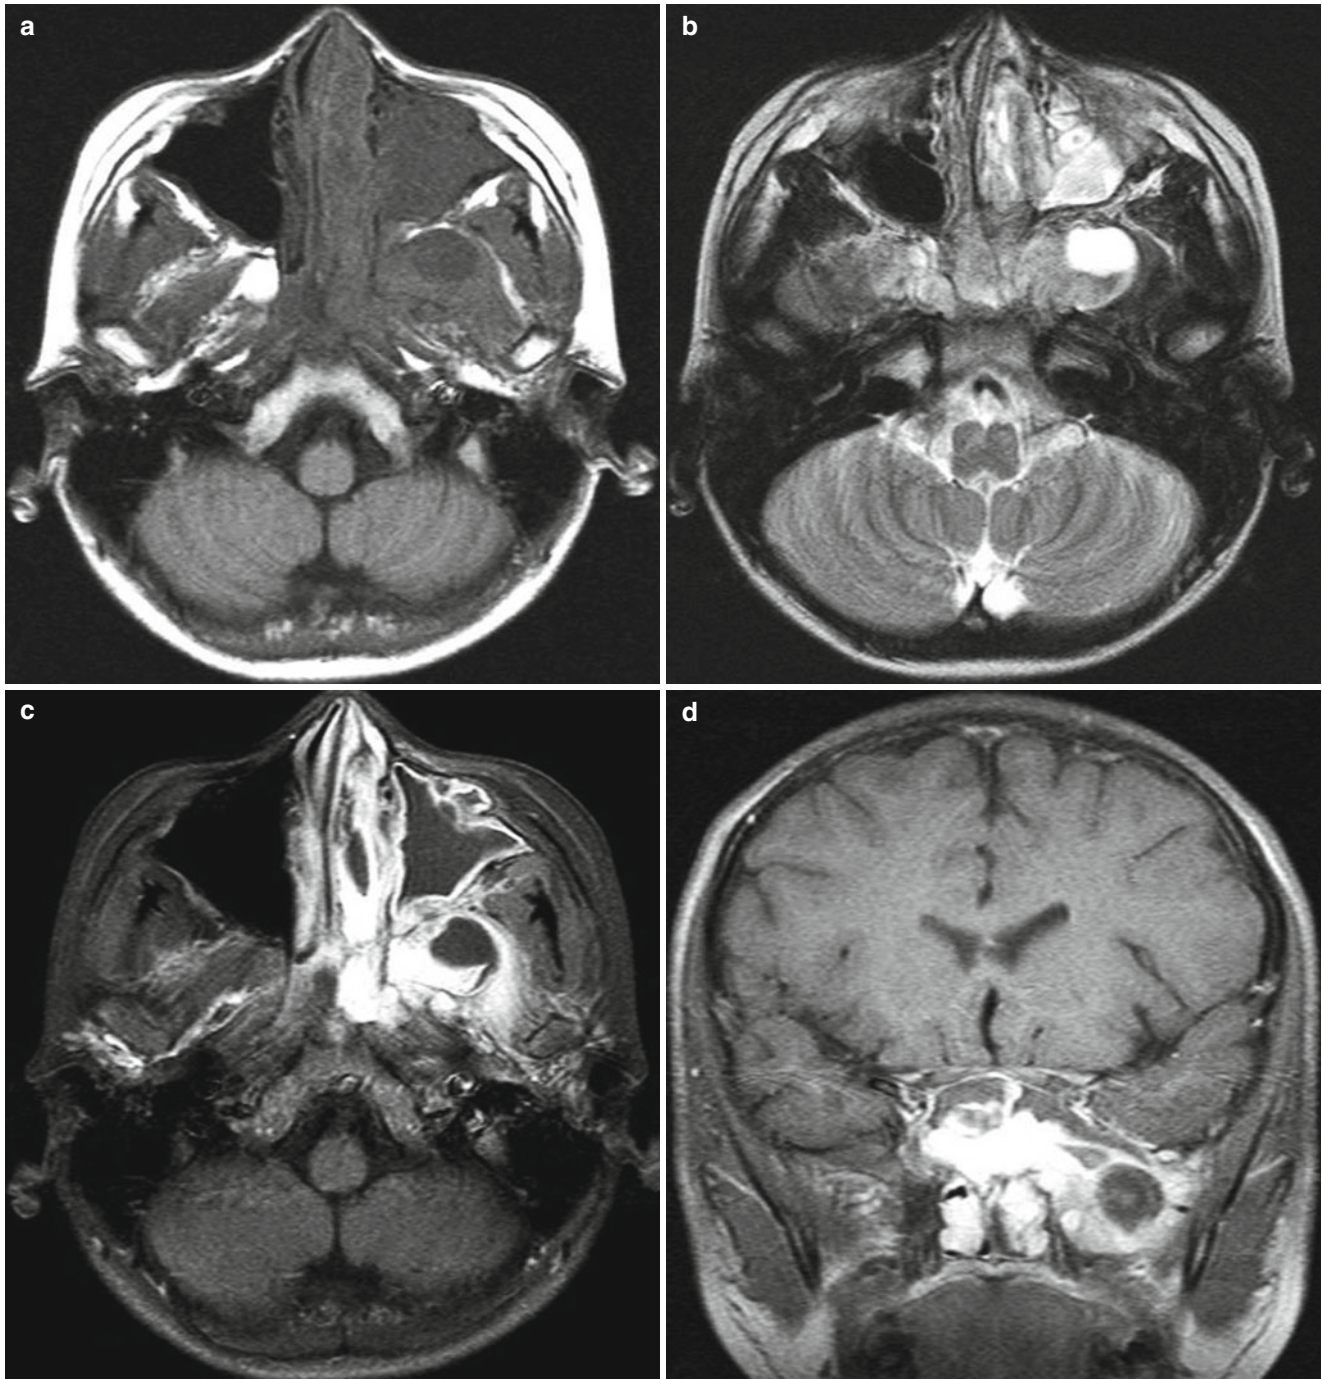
Nasopharyngeal angiofibroma in a 10-year-old boy. (a) Axial T1-weighted MR image shows an ill-defined heterogeneous soft tissue mass of iso- to low signal intensity relative to muscle involving the left nasal cavity and nasopharynx. (b) Axial T2-weighted MR image shows heterogeneous iso- to high signal intensity of the mass with internal cystic portion. (c, d) Contrast-enhanced T1-weighted fat-suppressed axial and coronal MR images show a large, intensely enhancing tumor
